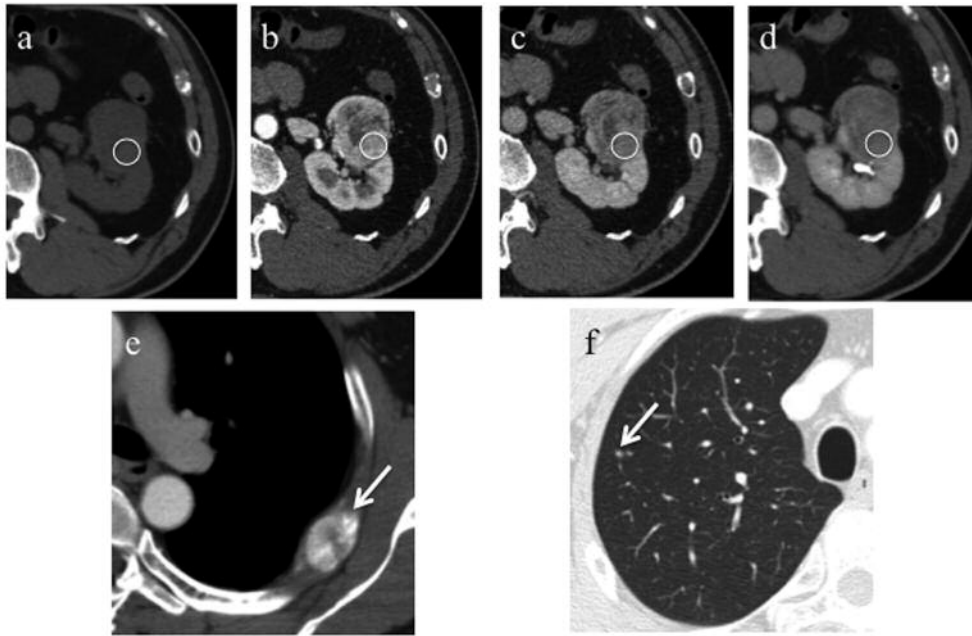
Pre-contrast (a), corticomedullary phase (b), nephrographic phase (c), excretory phase (d), and postoperative (e and f) chest computed tomography (CT) for a 58-year-old female with 3.8-cm clear cell renal cell carcinoma showing low $TA_{neph} - TA_{pre}$ (ΔTA_{neph}). Preoperative dynamic CT revealed a heterogeneously enhanced mass in the left kidney (a-d). On each image, a region of interest was placed to cover as much of the solid region of the mass as possible, while avoiding hemorrhage, degeneration and necrosis. The TA_{pre} , TA_{cor} , TA_{neph} and TA_{ex} values were 47.7, 181.6, 120.5 and 100.9 HU, respectively. ΔTA_{neph} was 72.8 HU. Chest CT 44.1 months after surgery showed lung (e) and bone (f) metastases (arrows). TA_{pre} , TA_{cor} , TA_{neph} , TA_{ex} : Pre-contrast, corticomedullary, nephrographic and excretory phase tumor attenuation, respectively.
